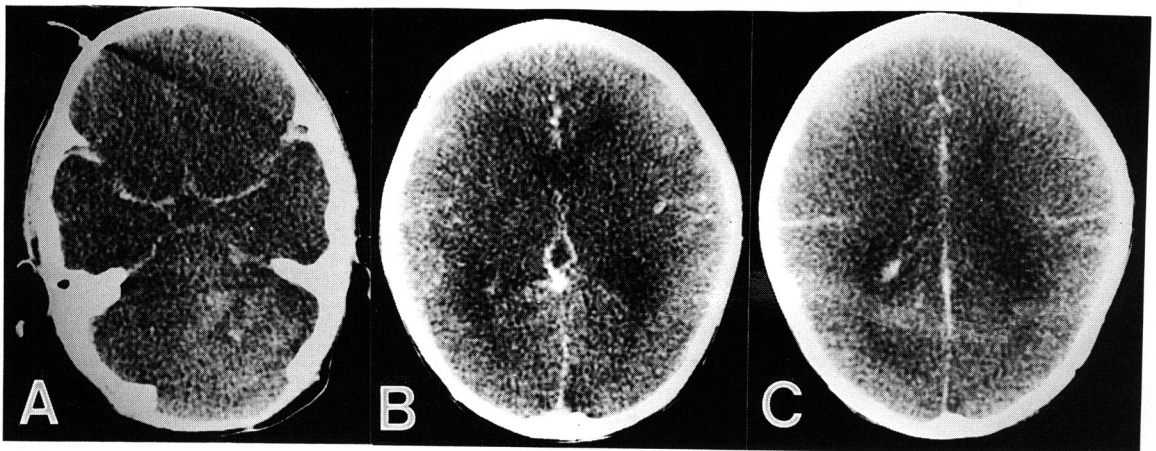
Preenhanced CT shows apparent increased density at the base of the brain along the course of the circle of Willis and middle cerebral arteries (A), and abnormally dense-appearing deep venous structures (B, C). Diffuse decrease in the brain density and poorly delineated ventricular system are also noted.
